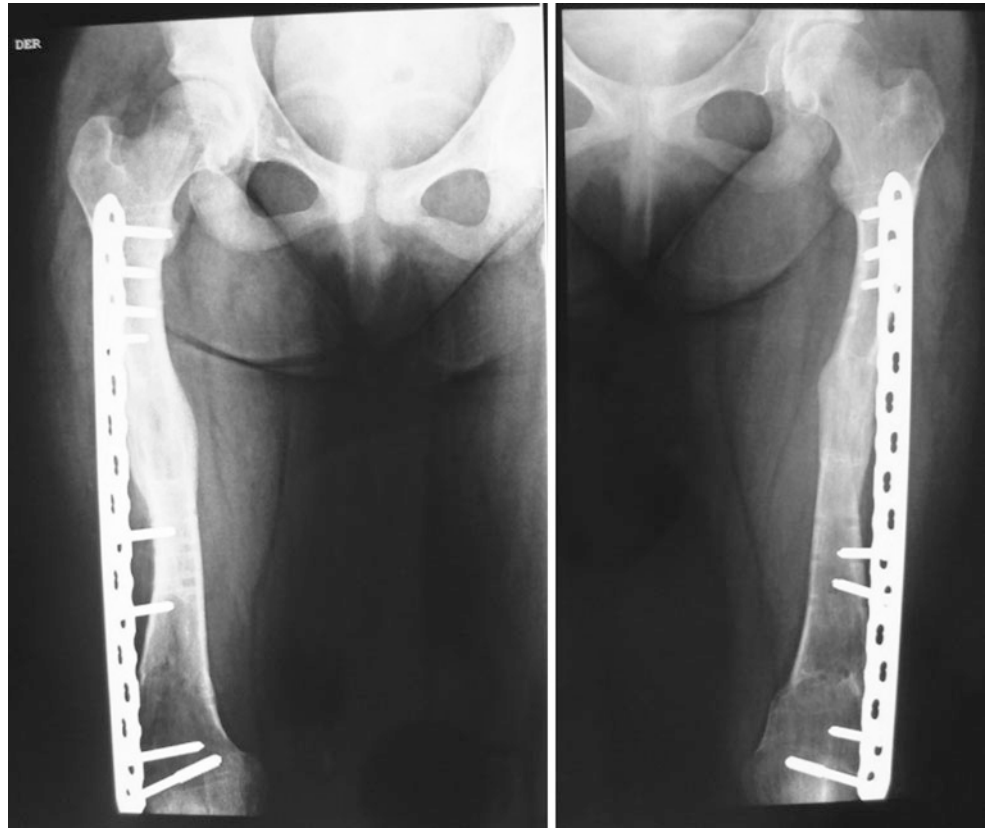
Bilateral femur lateral X-rays showing union and deformity correction with locked plates in place. Note that the plates are positioned antero-lateral which is off plane from the fixators which were positioned from the lateral side
